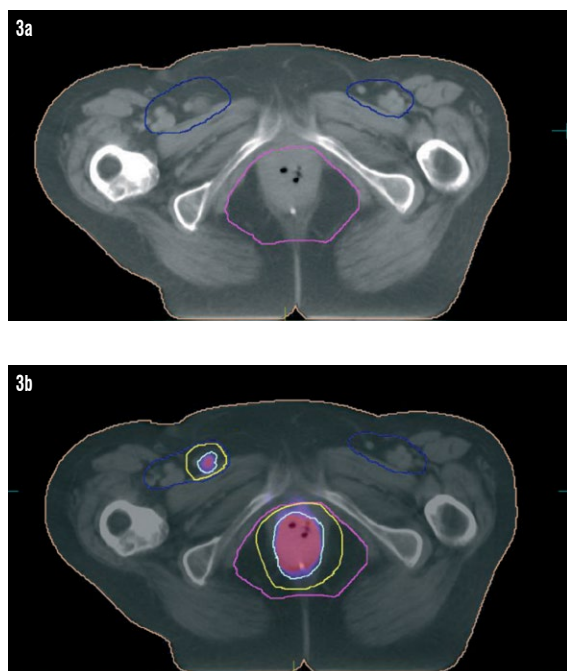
Difference between the CT based delineated contours without the PET data used for treatment planning (Figure 3a), and CT based contours with the PET data fused (Figure 3b)
